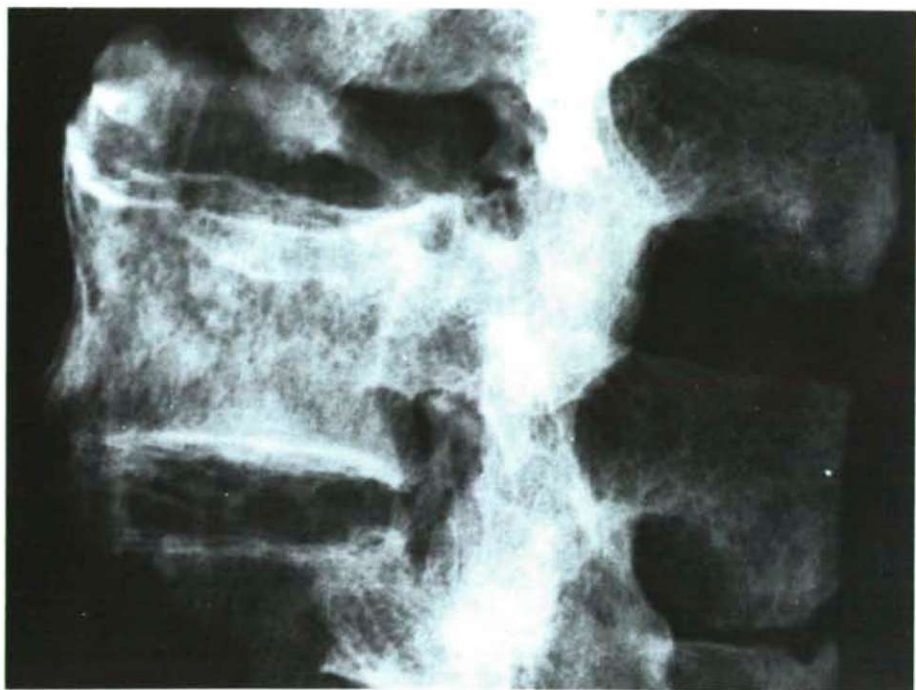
Radiograph of the vertebrae seen on Fig.3. Finding Nr. 5791, grave Nr. 67. Male, 40-50 years of age
